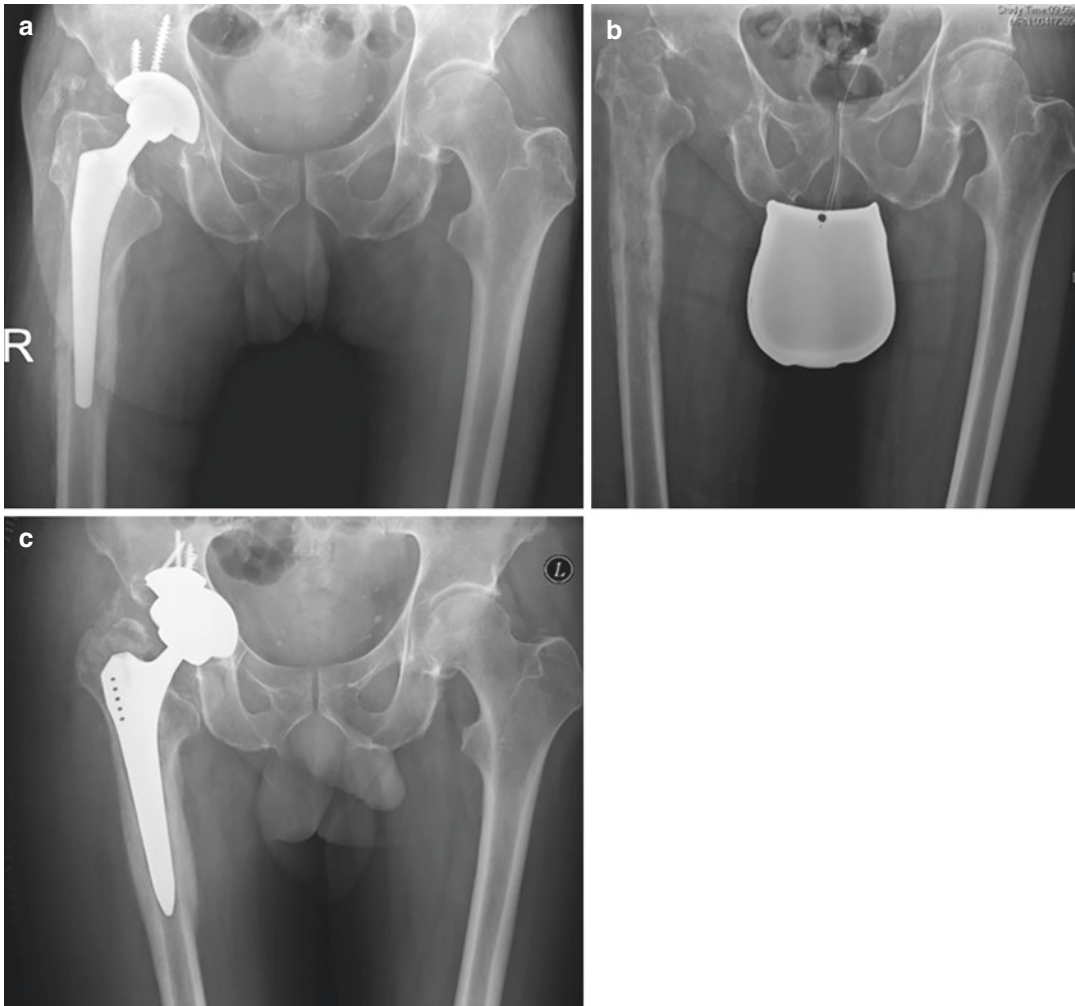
Radiographs showing treatment of a 67-year-old patient with an infected hip prosthesis. Two-stage septic revision via an ABMS approach of an infected left hip prosthesis (*Staphylococcus aureus*) (a) Pelvis radiograph pre-operatively. (b) Prosthesis-free interval of six weeks
